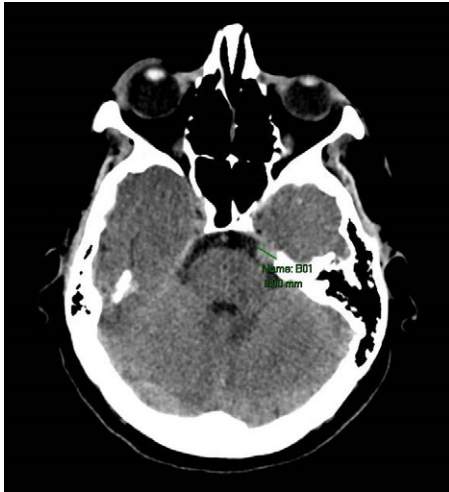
CT scan demonstrating a contrast-enhancing lesion in the left pre-pontine region, likely to be a trigeminal schwannoma or metastatic deposit.
